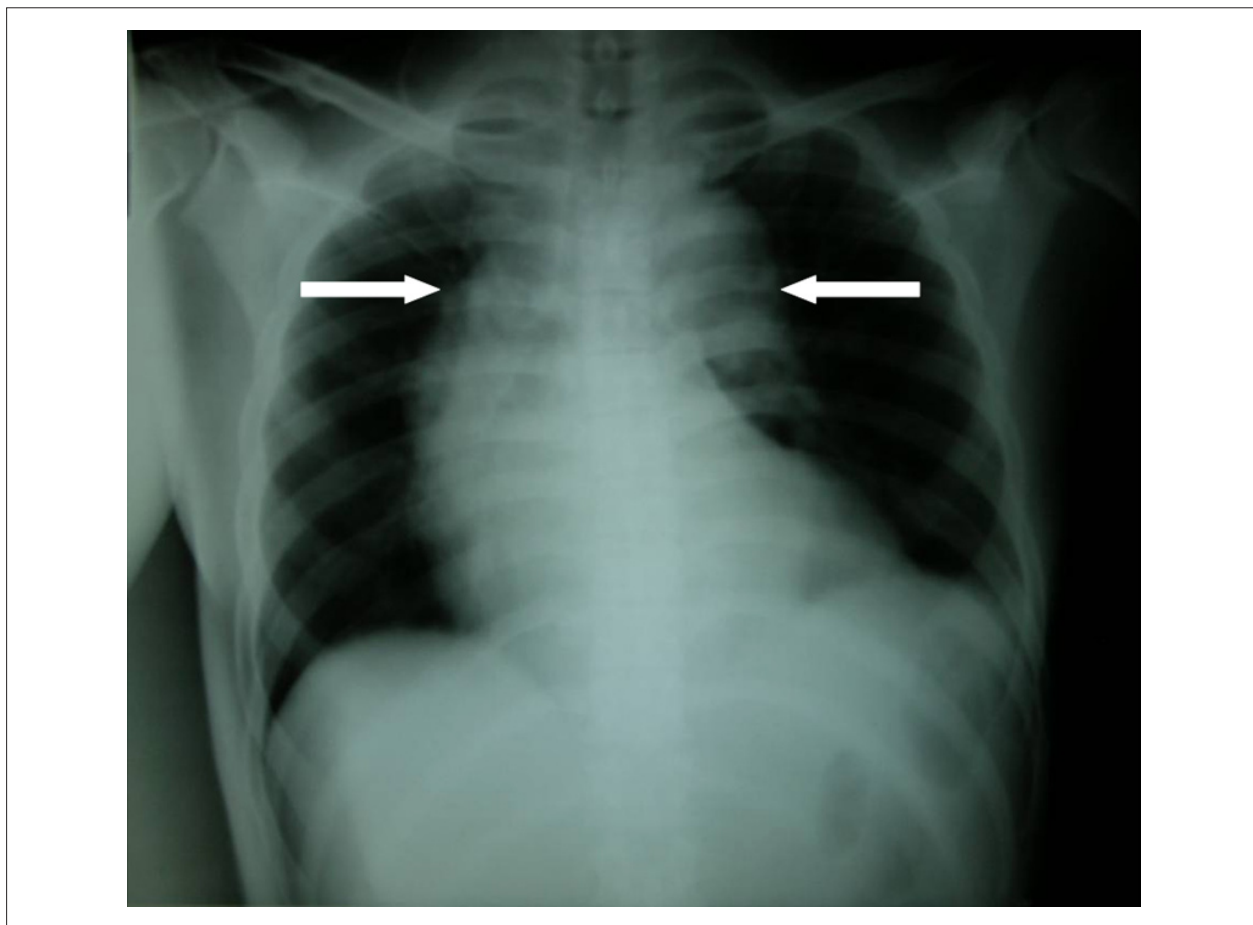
Plain chest X-ray showing mediastinal widening (arrow) suggestive of thoracic aortic aneurysm.
